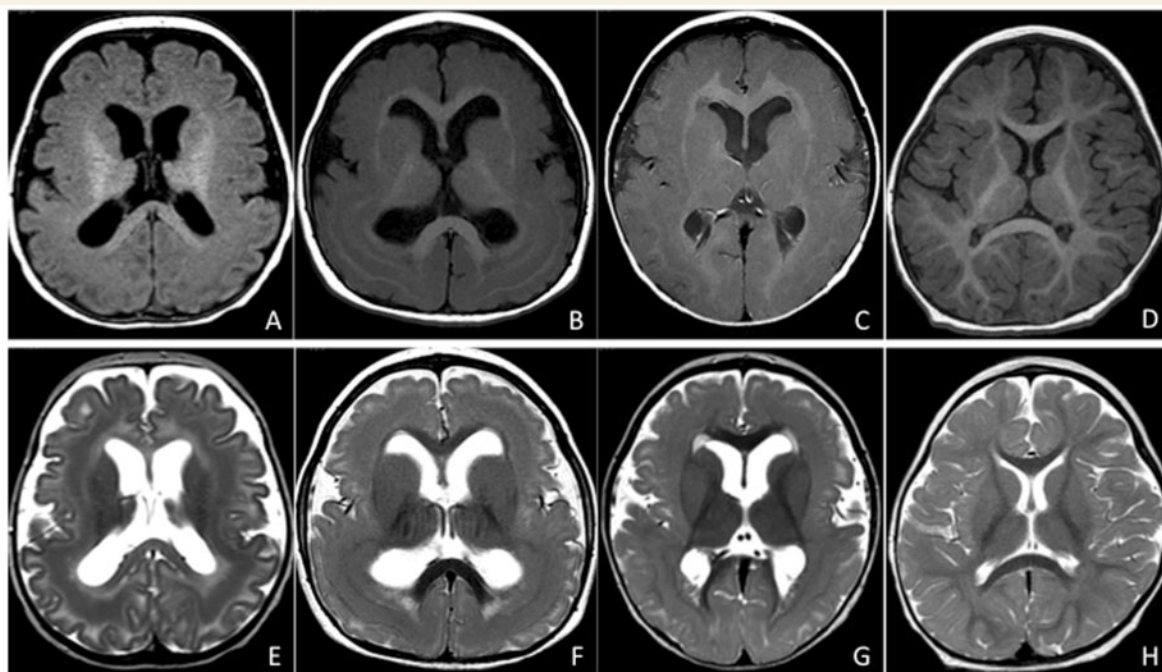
Representative axial MRI in young children aged 7 months (A and E), 14 months (B and F) and 17 months (C and G). T₁-weighted images show poor differentiation of the cortex and underlying white matter, with an aspect reminiscent of diffuse pachygyria (in younger child, A), or frontoparietal pachygyria combined with band heterotopia in posterior regions (in patients > 1 year of age, B and C). At the same level, on T₂-weighted images, the band is visible (E, F and G). Control MRI: T₁-weighted image (D) and T₂-weighted image (H) in a normal 15-month-old female.
